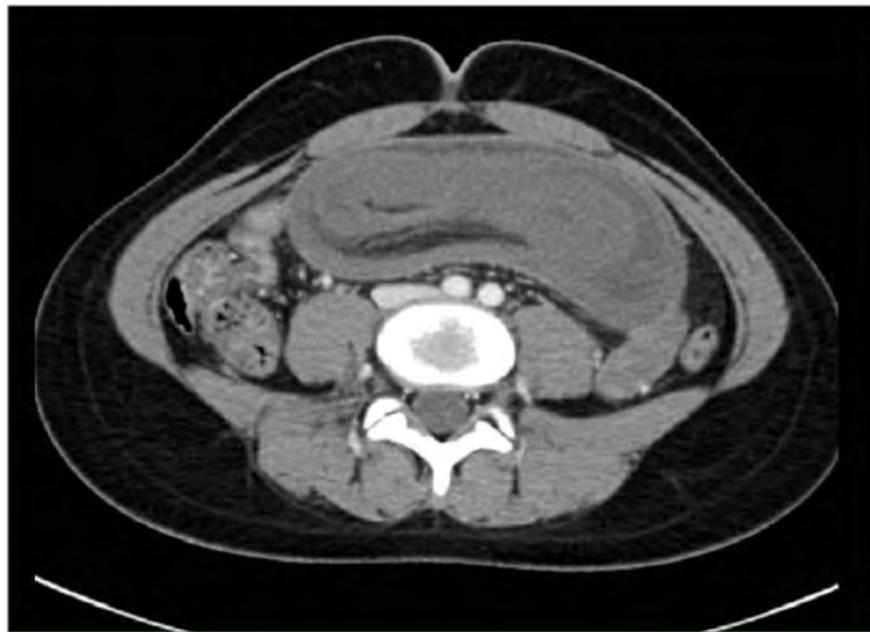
CT showing the sausage shaped mass.
